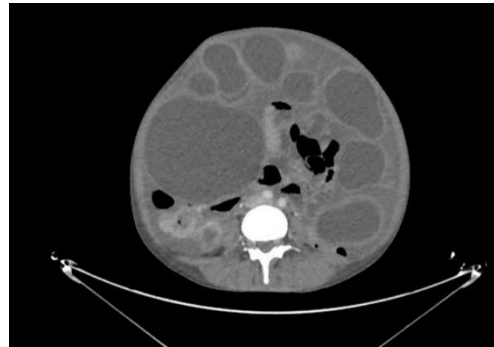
CT of the abdomen, pelvis, and chest multiple hydatid cyst in abdomen cavity.
